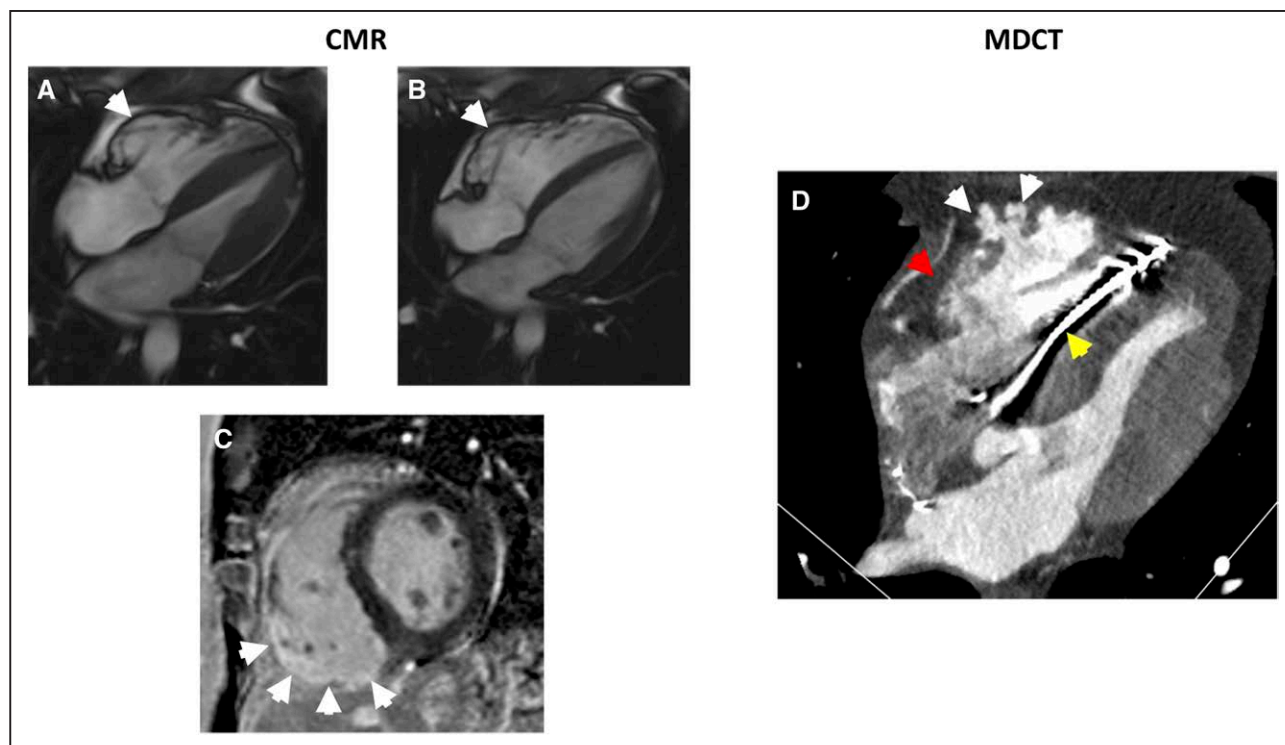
Features of arrhythmogenic right ventricular cardiomyopathy (ARVC) on cardiac magnetic resonance (CMR) and multidetector computed tomography (MDCT).
